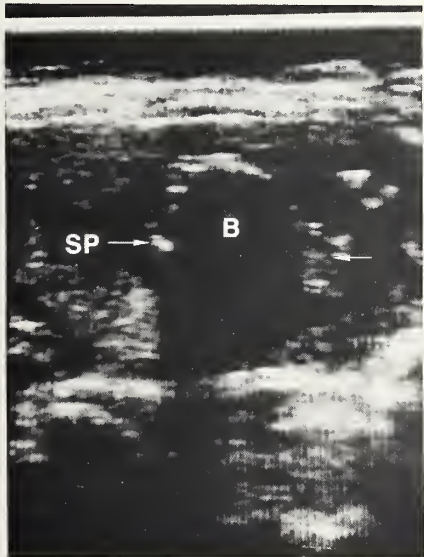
Protrusion of the pulsating heart (arrow) outside the fetal body (B) was noted on ultrasound. (SP = spine).
